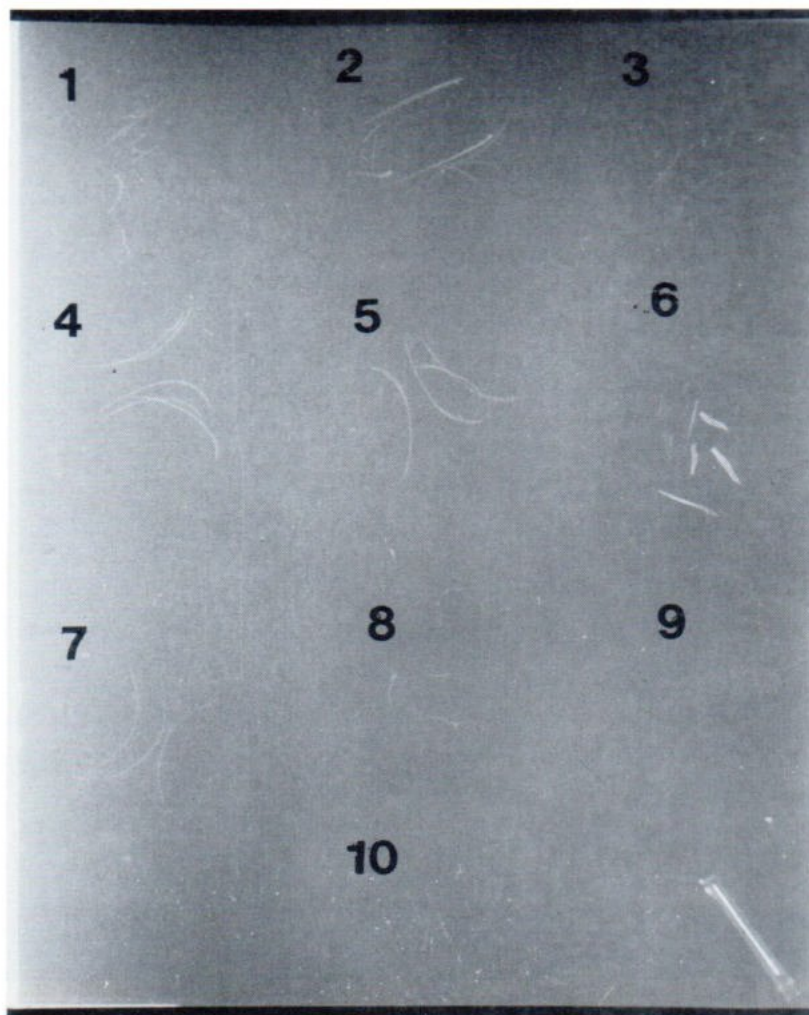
Radiograph of the dried fish bones prior to implantation labelled as follows
